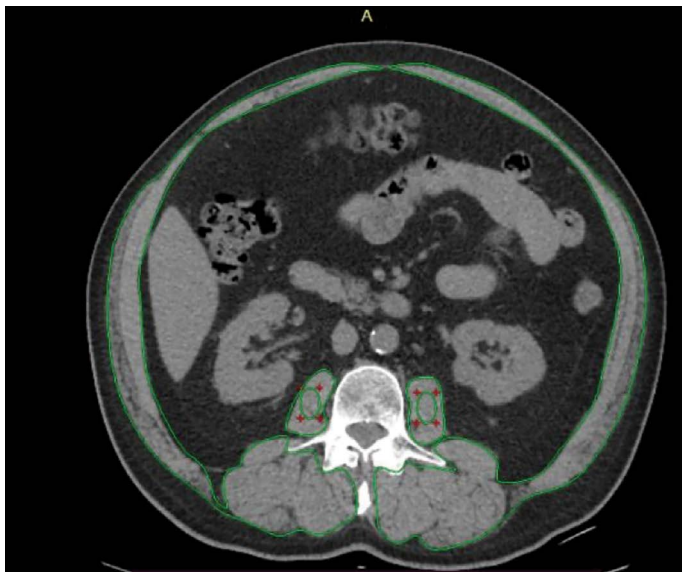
Axial abdominal computed tomography image at the level of third lumbar vertebrae. Skeletal muscle area, psoas area and psoas density was calculated with semi-automatic method.
